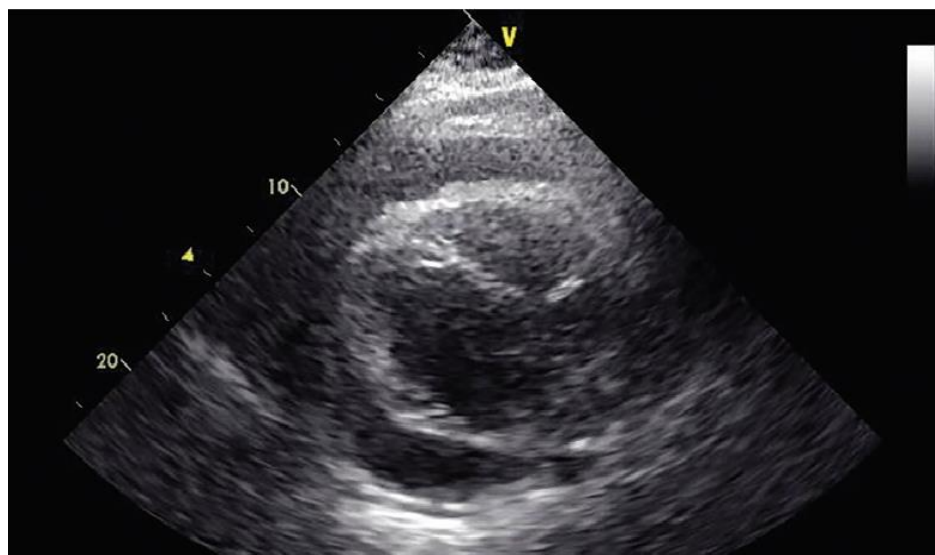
Echocardiographic examination of the heart in the parasternal long axis position showing pericardial effusion.
